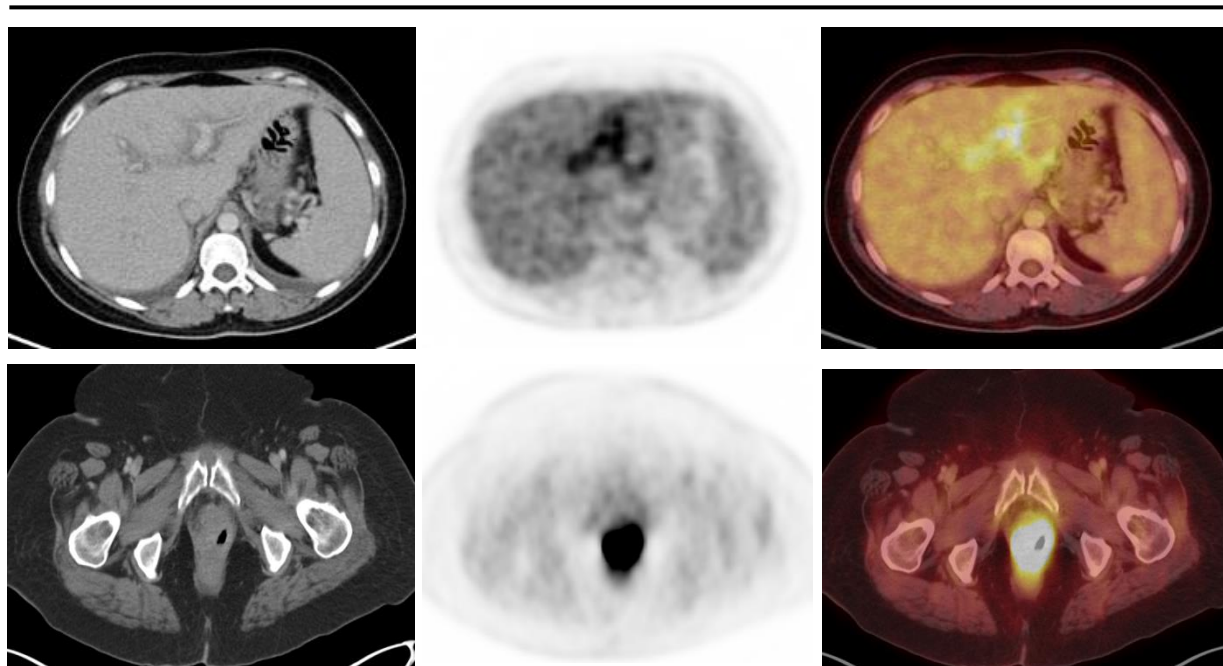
58-y-female patient with pathologically proven SQ.C.C cervical carcinoma. She underwent total abdominal hysterectomy and bilateral oophorectomy and received post-operative chemo- and radio-therapies. After 5 months and on follow up, she developed vaginal bleeding. F-18 FDG PET/CT performed and revealed; FDG avid cervical stump irregular soft tissue lesion with SUV max 23.6 and FDG avid peri-portal infiltrates of SUV max 8.
